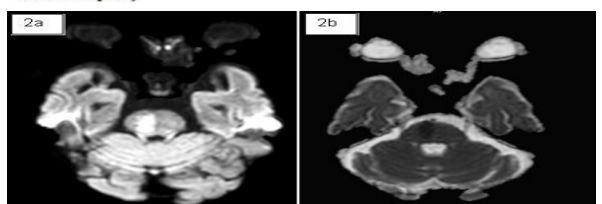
MRI brain - Intra axial images showing restriction diffusion with ADC reversal in the right Hemipons
